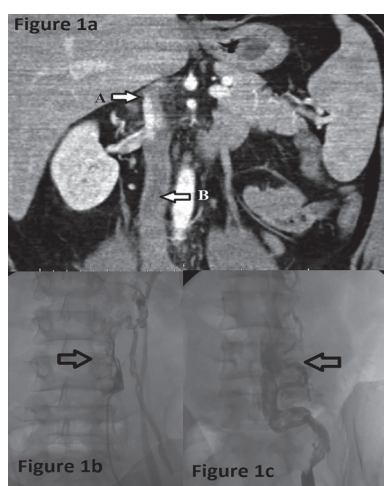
Young male with deep vein thrombosis associated with supra-renal inferior vena cava agenesis. a) Computed tomography reveals that interruption of inferior vena cava at supra-renal level (arrow A) and thrombosed inferior vena cava (arrow B). b) Initial venogram indicated that thrombosed infrarenal inferior vena cava and large lumbar veins (arrow). c) Partial recanalization after EKOS (arrow).
